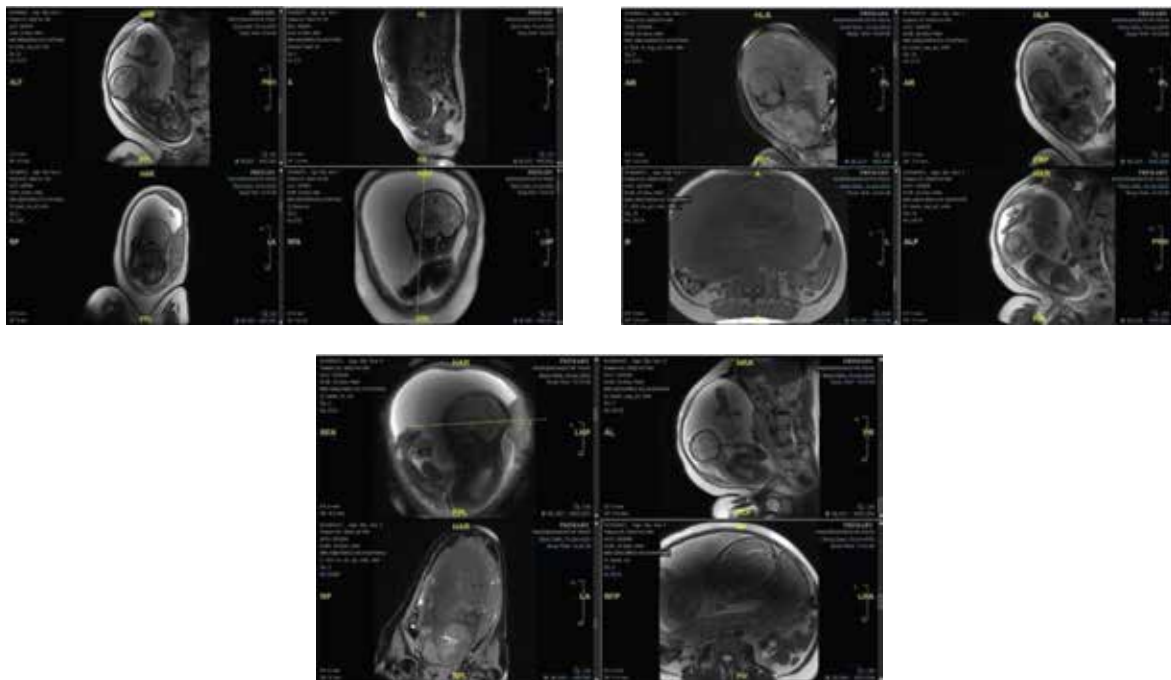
Maternal Abdominal MRI for The First Baby
